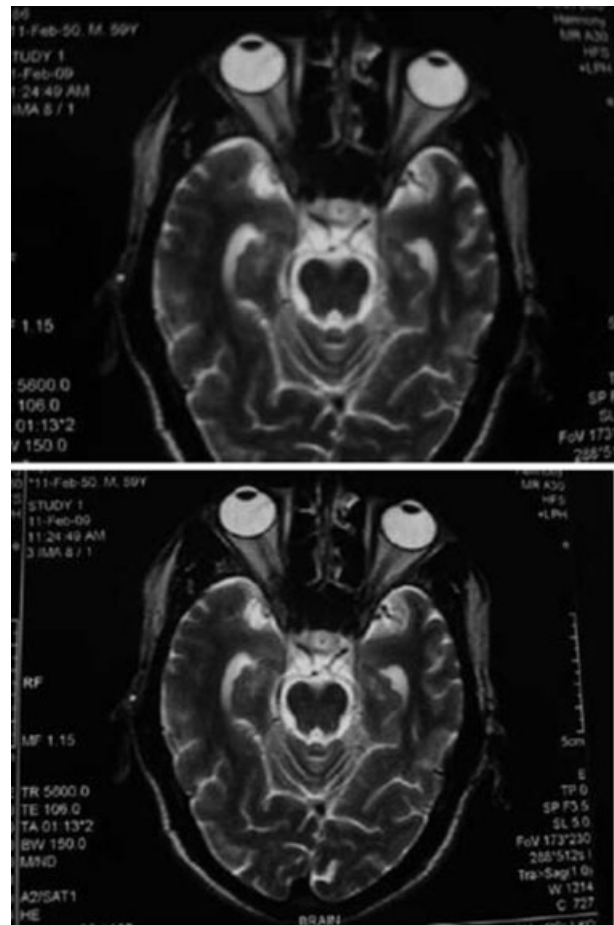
Magnetic resonance imaging after 6 months showed resolution of all lesions.
